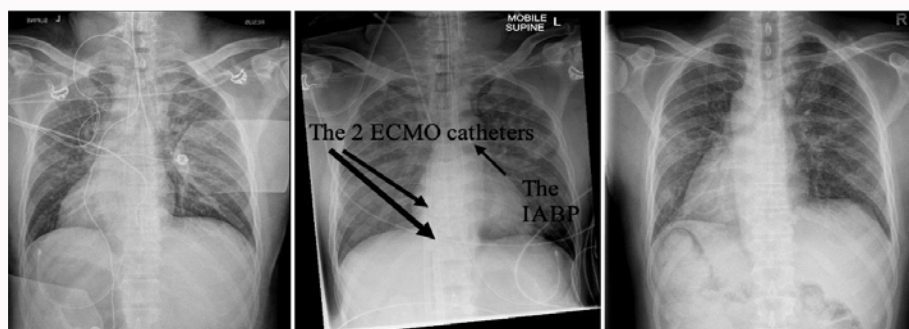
Antero-posterior chest X-rays.
